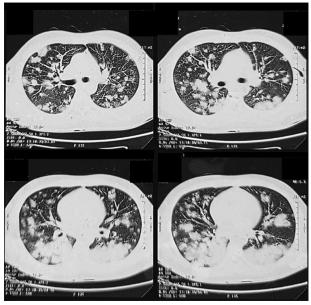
Computed tomography images showing large nodules with "feeding vessel sign" with septal thickening, with peri-septal nodules
